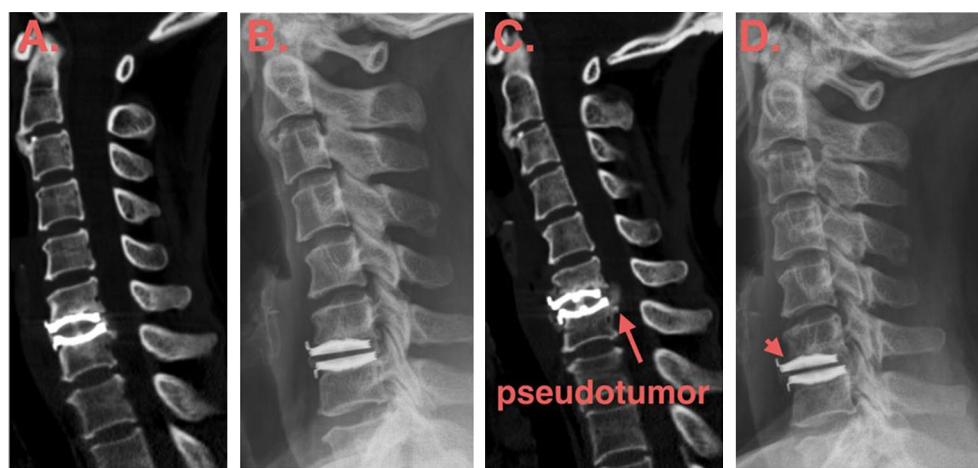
a Postoperative cervical spine CT (on bone window), 6 years after initial surgical intervention, shows the proper position of the Bryan Disc with mild heterotopic ossification. b Cervical spine radiograph at 6 years after initial cervical arthroplasty. c Cervical spine CT one and a half years after the traffic accident shows high-density
